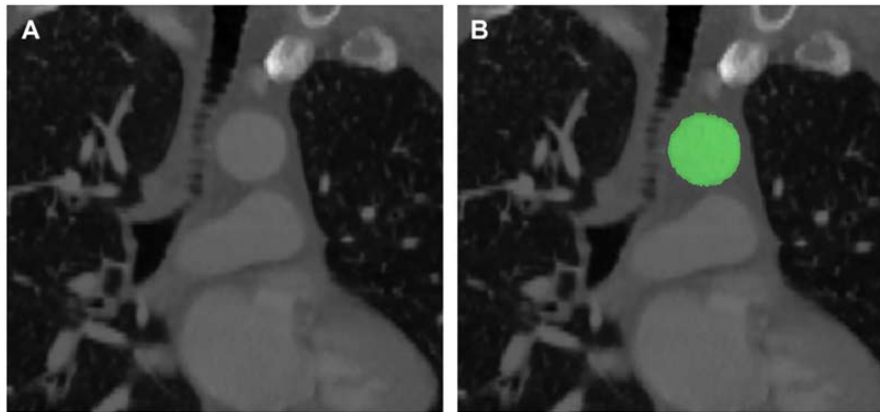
CTA with intravenous contrast demonstrates excellent image quality identifying the aortic lumen (A). Custom designed image segmentation software determines area and diameter changes based on this segmentation (B). Figure is taken from the work of Muhs et al. (2006).
